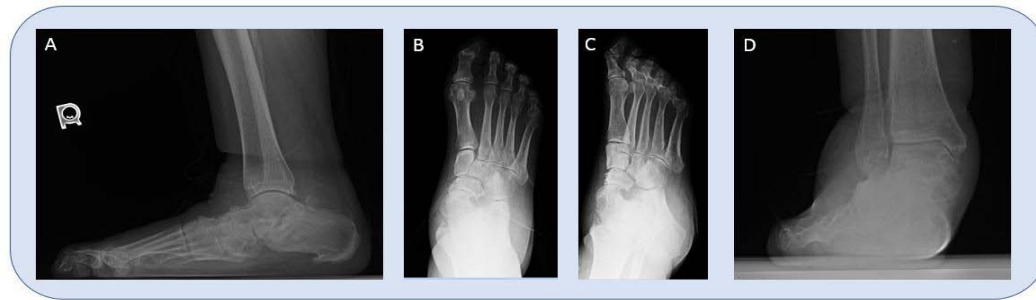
Pre-operative lateral (A), Anteroposterior (B), Medial Oblique (C) of the right foot; Anteroposterior radiograph of the right ankle (D). Foot is in a planovalgus position as evidenced by radiographs.
